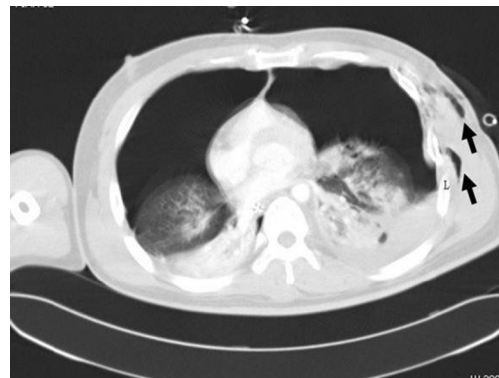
Chest computed tomography reveals bilateral pneumothoraces and subcutaneous emphysema (arrows).
